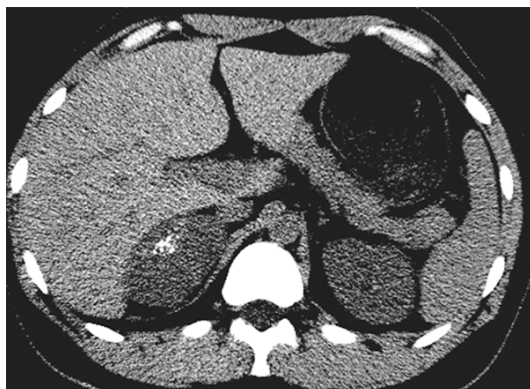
A 63-year-old male with non-functional adenoma of the right adrenal gland. The mass shows stippled calcification on non-enhanced CT.
